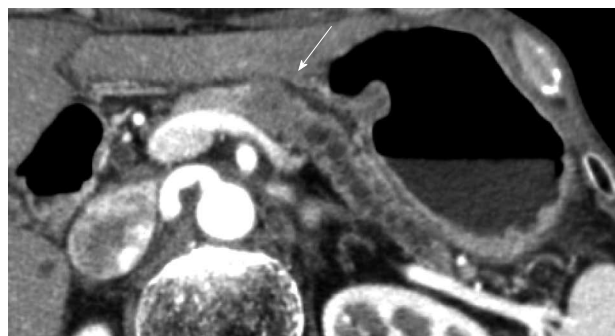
Computed tomography showing a 20-mm mass lesion in the pancreatic body (arrow).
